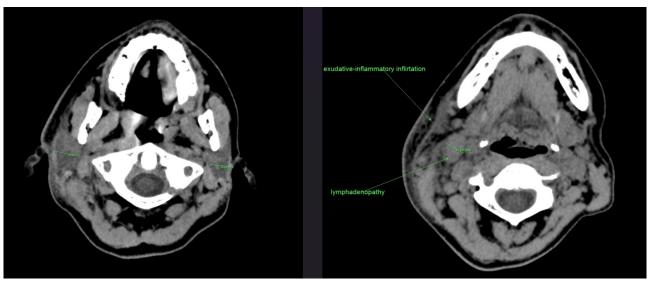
Images of salivary gland inflammation (sialadenitis) on CT scan without administration of contrast agent. Asymmetric enlargement of the right parotid gland, increased density of the surrounding subcutaneous tissue in the presence of exudative-inflammatory strands and localised lymphadenopaty can be seen.
